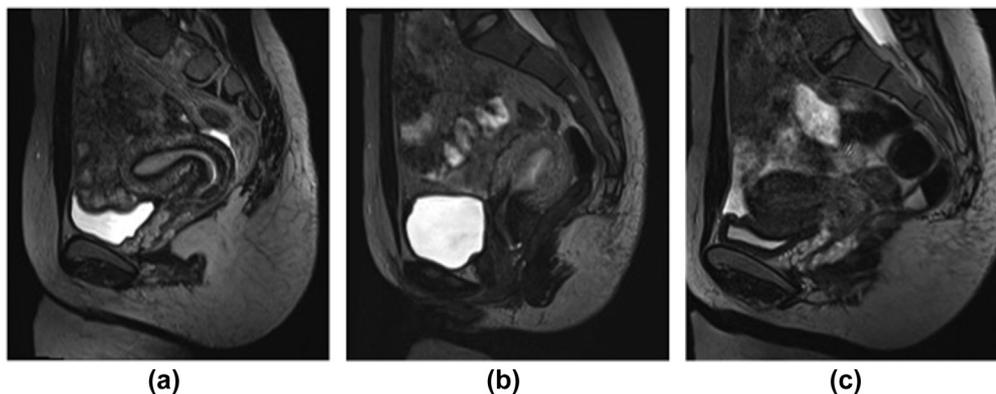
Examples of the three-point Likert-scale scoring system on the evaluation of boundary sharpness of uterine three zonal structures on high-resolution 3D T2-weighted images in mid-sagittal plane. (a) The uterus of a 25-year-old volunteer in the OP. The boundary sharpness of the uterine three zonal structures was well-defined with score of 3. (b) The uterus of a 22-year-old volunteer in the LP. The boundary between the junctional zone and myometrium was obscured with a score of 2. (c) The uterus of a 26-year-old volunteer in the MP. The boundary between junctional zone and myometrium was ill-defined with score of 1.
